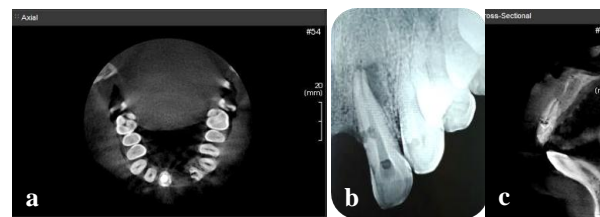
(a). CBCT scan: cross sectional slice (b) Preoperative compute radiograph labial view (c) CBCT scan: axial slice.
